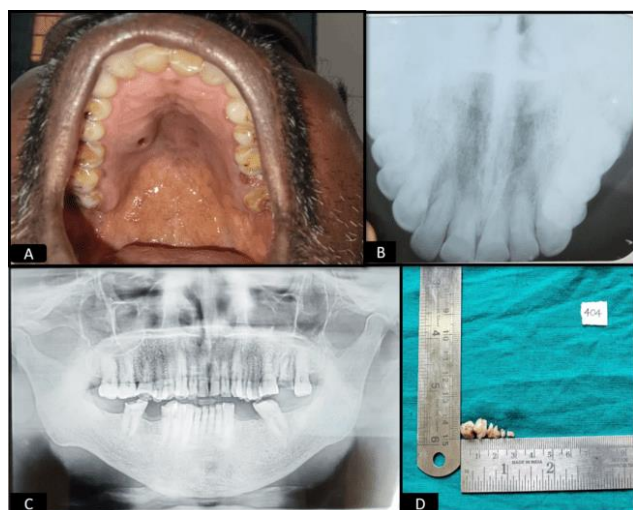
A): Palatal swelling with ulceration seen on the left posterior hard palate. B&C): Occlusal radiograph & Orthopantomogram showed no significant changes. D): Incisional biopsy consists of fragile soft tissue bits
